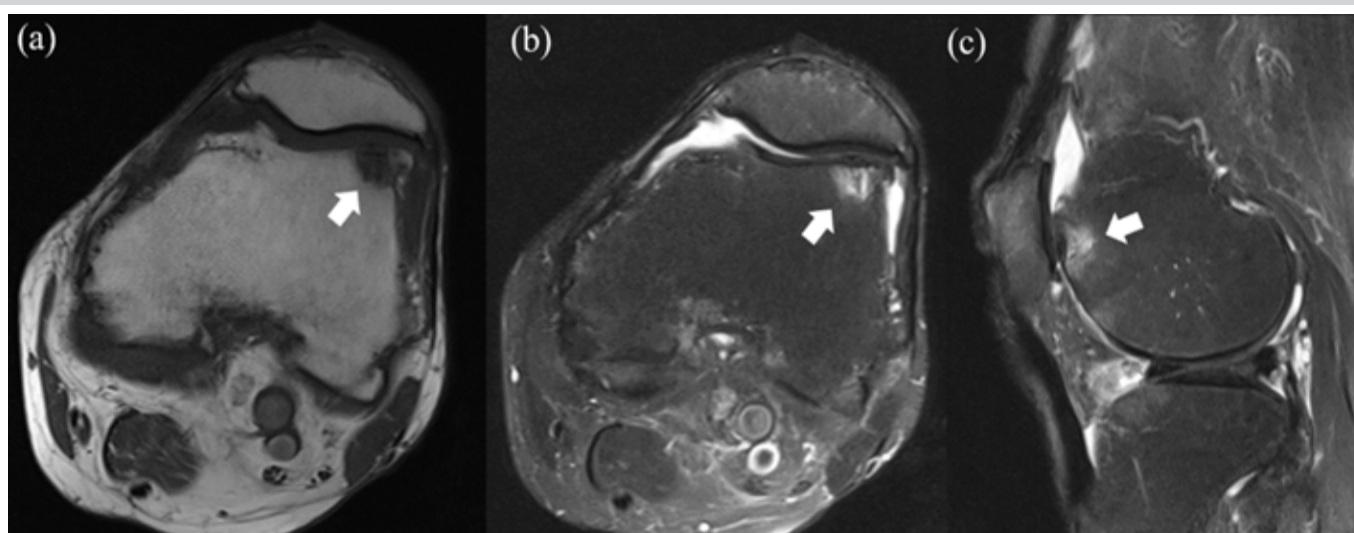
Bone marrow edema is observed in the osteophyte area on the lateral side of the femoral trochlea (white arrow). (a) Axial view of T1-weighted image (b) axial view of fat-suppressed T2-weighted image (c) sagittal view of fat-suppressed T2-weighted image.
